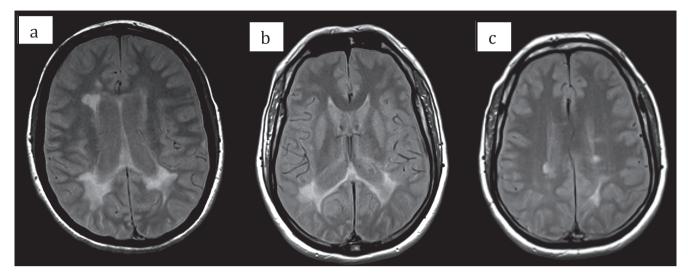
Brain MRI (axial sections, PD): a) case n^o 4: Multiple demyelinating lesions, with relative predominance in the parietal and occipital areas; b y c) case n^o 5: periventricular lesions y confluent plaques, parietal-temporal-occipital areas
